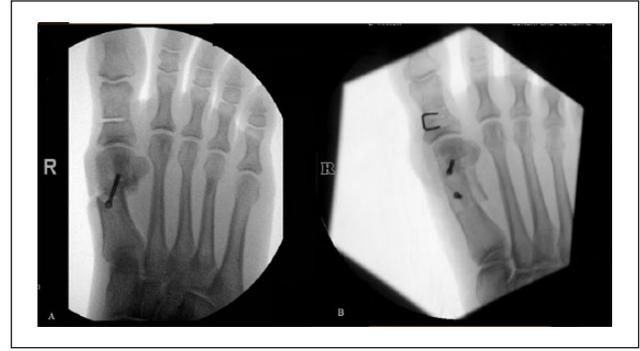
Intraoperative radiographs comparing (A) percutaneous chevron-Akin osteotomies and (B) open scarf-Akin osteotomies.
